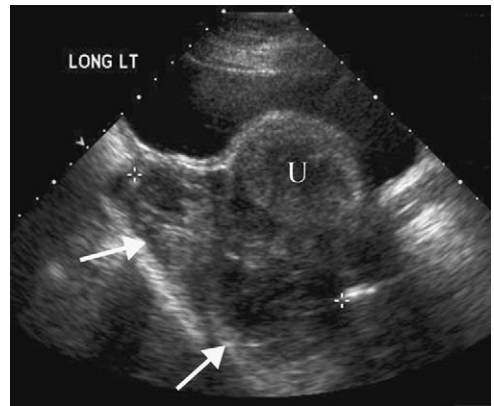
Acute bleed from a left hemorrhagic cyst. There is a clot (arrows) posterior to the uterus (U) on transabdominal ultrasound.
